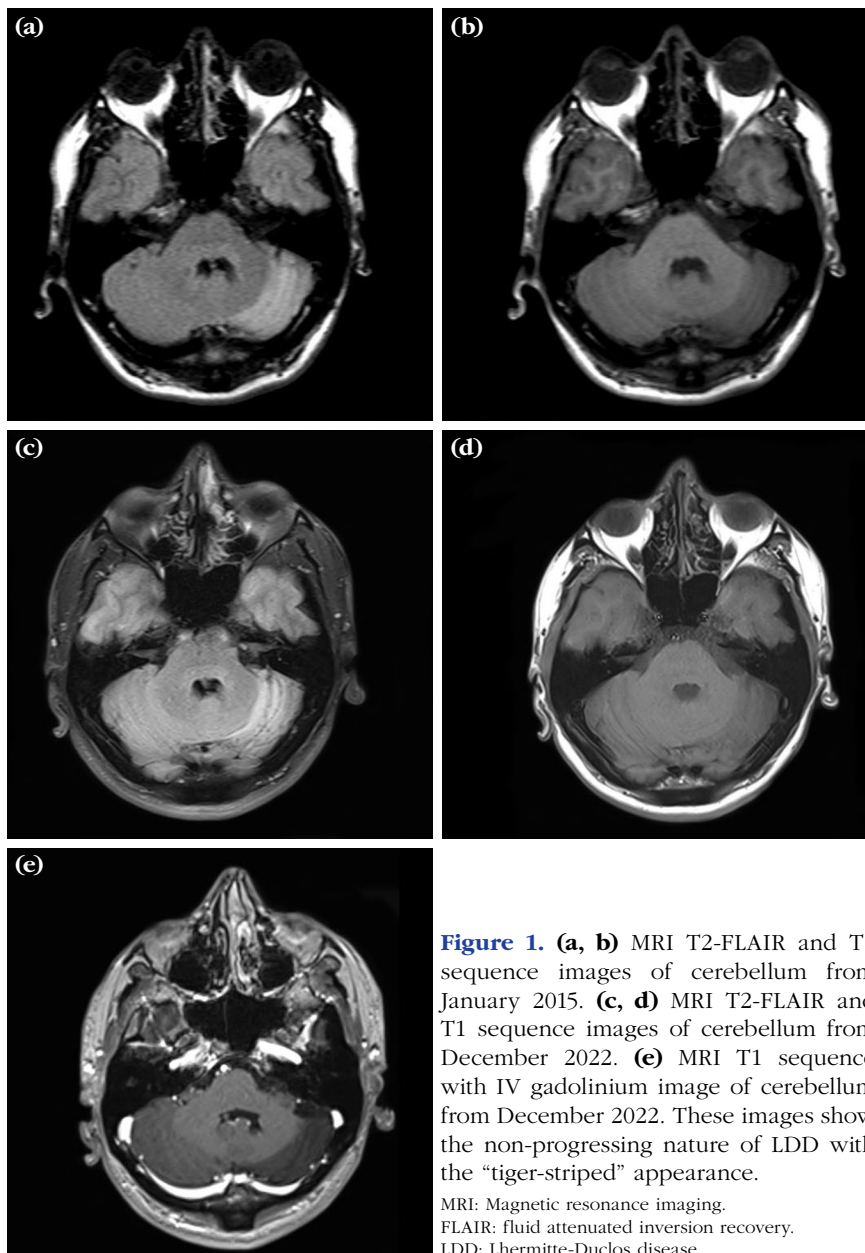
(a, b) MRI T2-FLAIR and T1 sequence images of cerebellum from January 2015. (c, d) MRI T2-FLAIR and T1 sequence images of cerebellum from December 2022. (e) MRI T1 sequence with IV gadolinium image of cerebellum from December 2022. These images show the non-progressing nature of LDD with the “tiger-striped” appearance.
